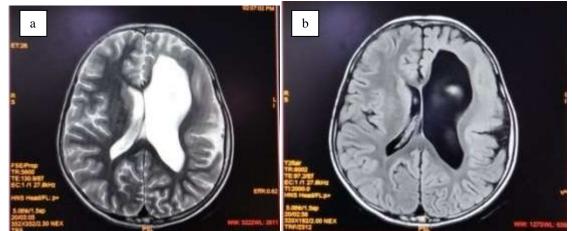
On axial sections of MRI Brain, T2/FLAIR shows left sided enlargement of lateral ventricle (predominantly frontal horn) with smoothening and thickeneing of the surrounding fronto-parietal cortex.
